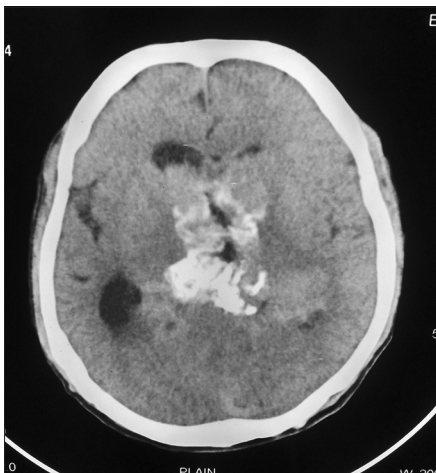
Computed tomography of the brain showing intracerebral calcification
